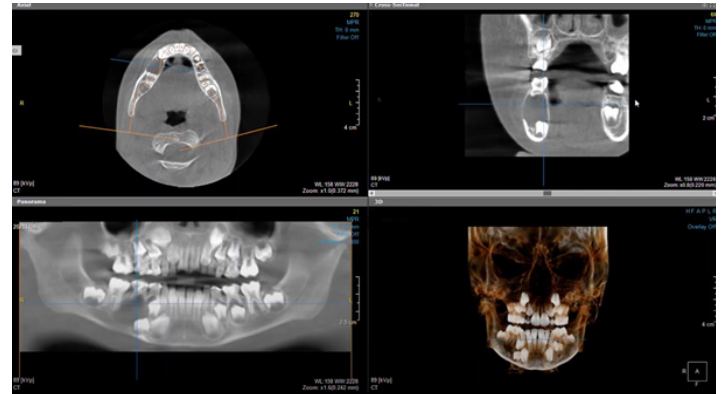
Pre-Operatif CBCT
